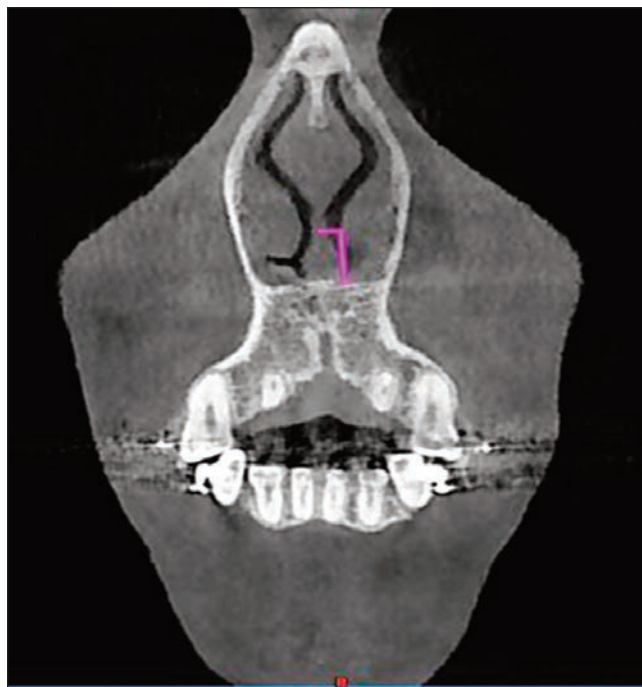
Nasal passage coronal computed tomography (CT) scans showing the wider side of the passage, and the distances between the septum and the inferior turbinate and between the hard palate (floor of the nose) and the inferior turbinate, measured in the internal nasal valve region.
